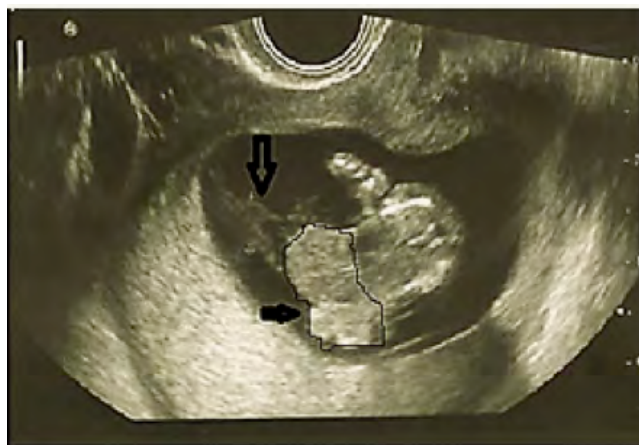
Ultrasound scan performed at 14 gestational weeks. Thin arrow points the protrusion of the fetal abdominal organs through the thoraco-abdominal wall defect. Thick arrow points the attachment between these structures and fetal amniotic membranes.
